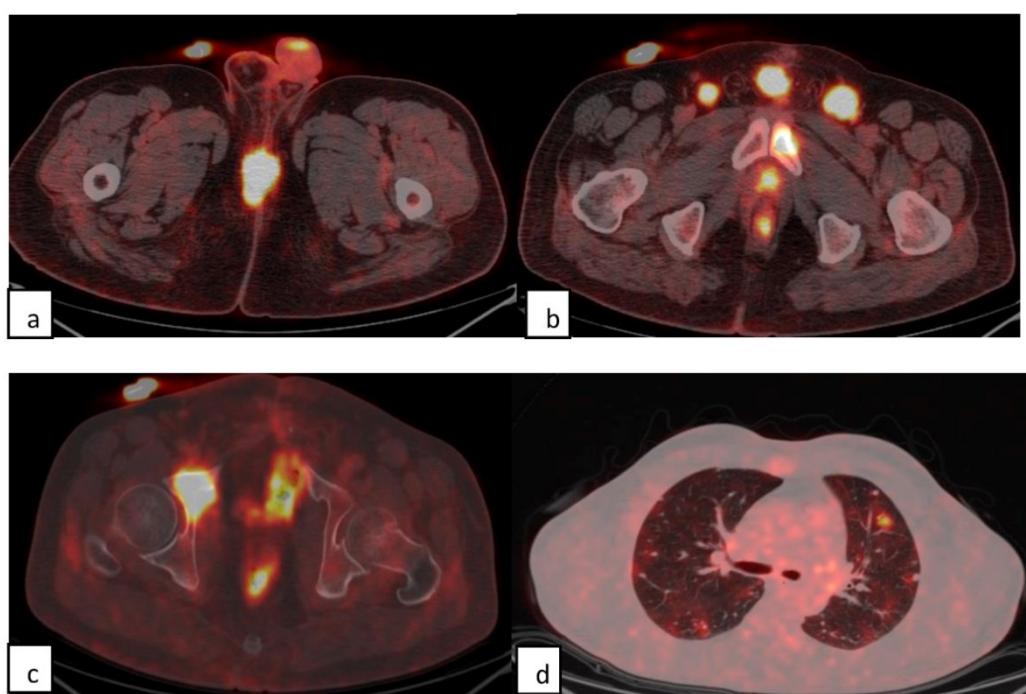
PET/CT axial fusion images showing high pathological uptake of [¹⁸F]FDG in: (a) penile shaft, (b) bilateral inguinal lymph nodes,(c) skeletal lesion of pelvic bone(d) and multiple bilateral pulmonary nodules
